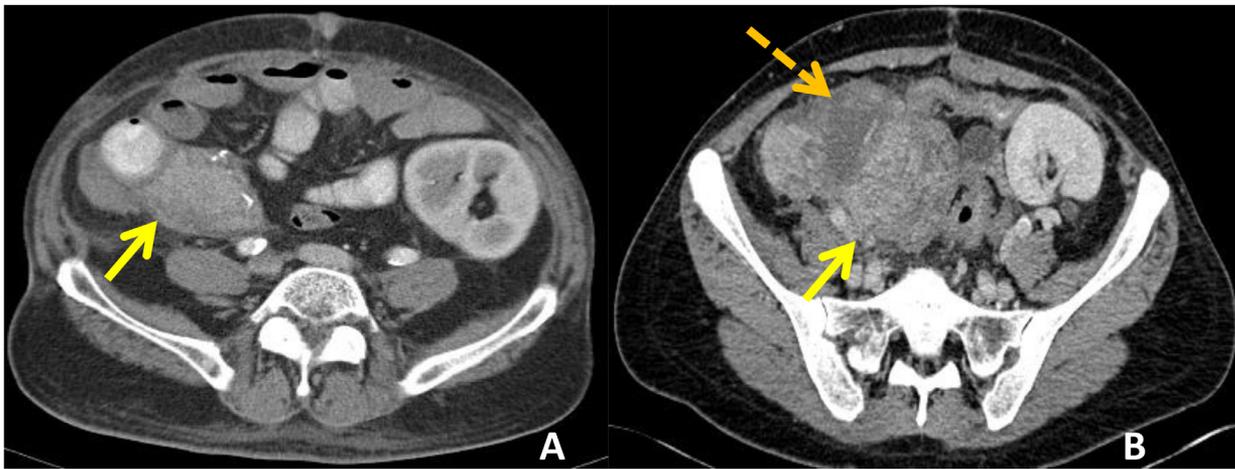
Graft pancreatitis can range from mild to severe in terms of its clinical presentation. Image A is an axial CT slice of a 55-year-old male 24 hours post-transplant which shows a transplanted pancreas (arrow) mild edema and heterogeneity of enhancement. This mild pancreatitis was asymptomatic and subsequently resolved without treatment. Conversely, Image B is an axial CT slice of a 41 year old female 2 months post-transplant with pain and fever demonstrating an enlarged, edematous graft (solid arrow) with heterogeneous enhancement and a peri-pancreatic fluid collection (dashed arrow). The patient underwent percutaneous biopsy demonstrating pancreatitis, and the patient was treated accordingly. (Color version of figure is available online.)
